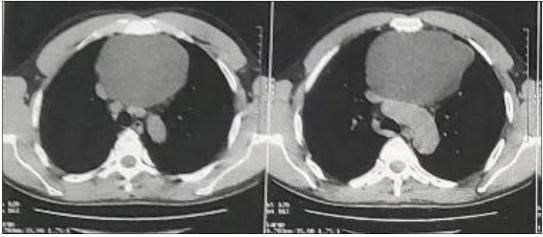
Chest CT scan in axial section and mediastinal window, showing a large anterior mediastinal cystic mass
